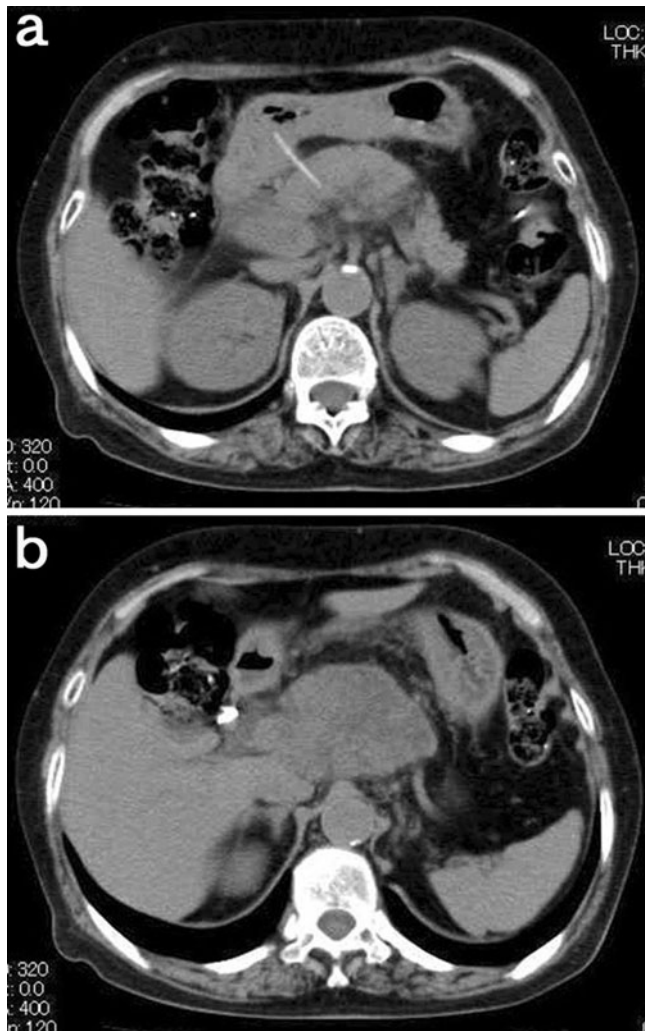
Computed tomography scan showed a linear calcified body that appeared to penetrate the posterior wall of the duodenal bulb into the pancreatic head (a), and swollen retroperitoneal tissue around the pancreas (b)
